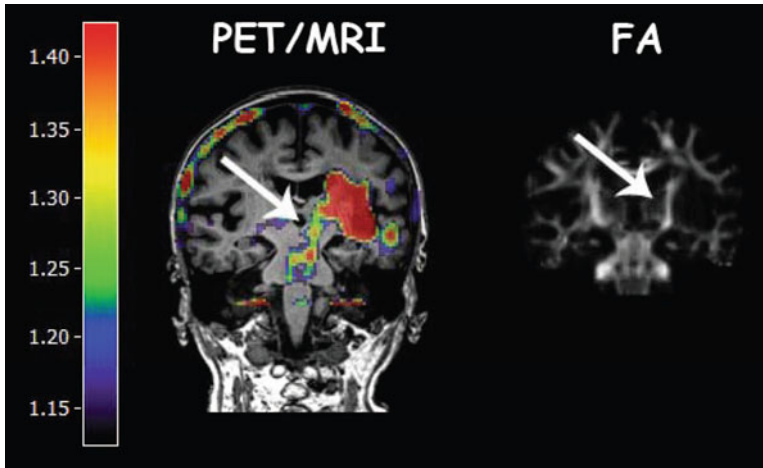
Activated microglia in a patient with left subcortical stroke imaged with [^{11}C]-PK11195 PET. Tracer binding is high in the infarct but extends along the pyramidal tract into the midbrain (*arrow*). The tract is visualized in the fractional anisotropy image from diffusion tensor MRI (*right*). From Thiel and Heiss, *Stroke* 2011 Feb 1;42(2):507–12
